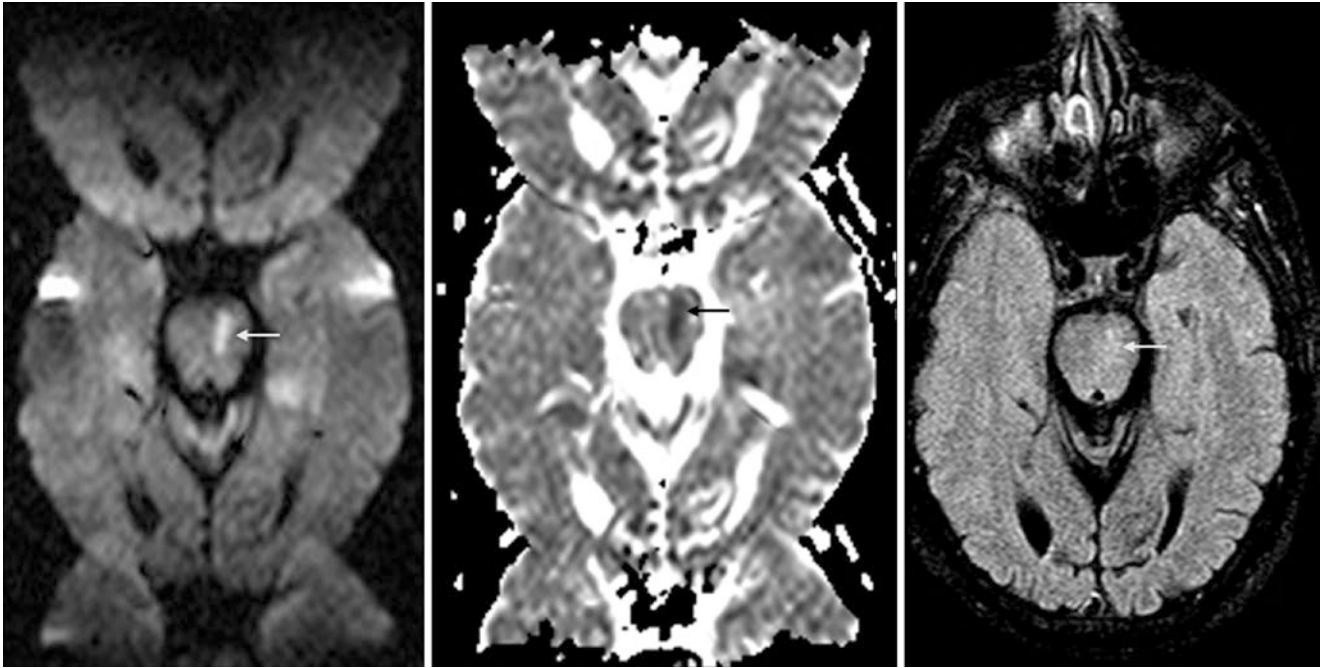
In a 3 T MRI of a 71-year-old, the axial DWI (*left*) and ADC map (*middle*) are affected by N/2 ghost artifact. This is represented as a shift of one half of the field of view in the anterior-posterior (AP) direction. This shift is not present on FLAIR (*right*), which does
